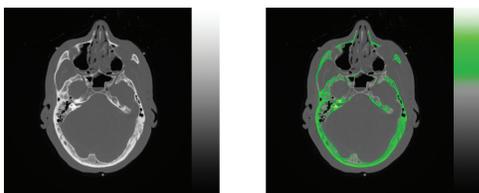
Bone tissue highlighted (green) in a CT scan.
